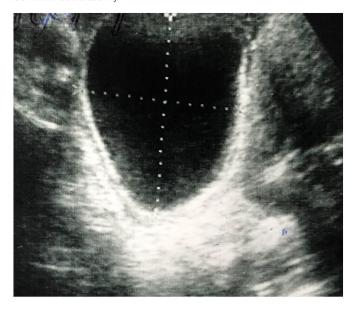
An ultrasound scan showing the cystic lesion with clear contents in the left ovary.
